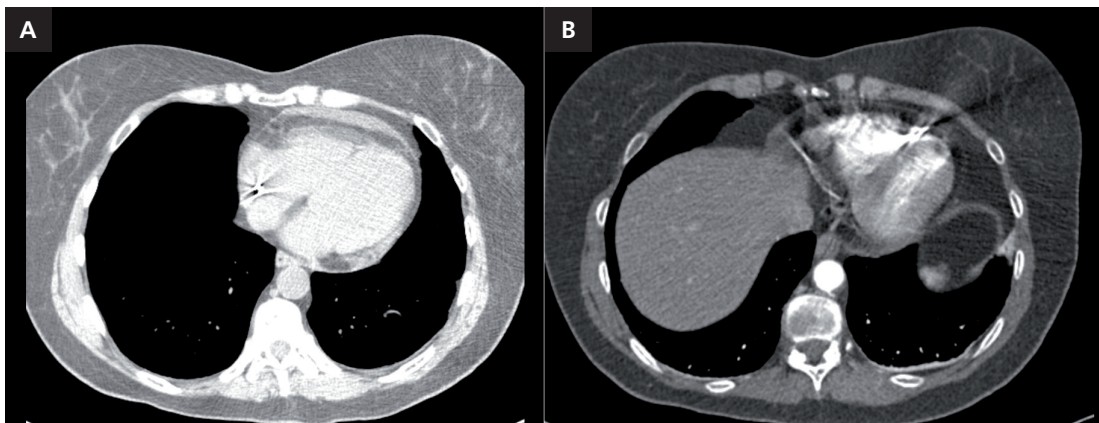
Contrast CT scan: (A) pericardial effusion; (B) intramyocardium placement of the right ventricular apical lead.
